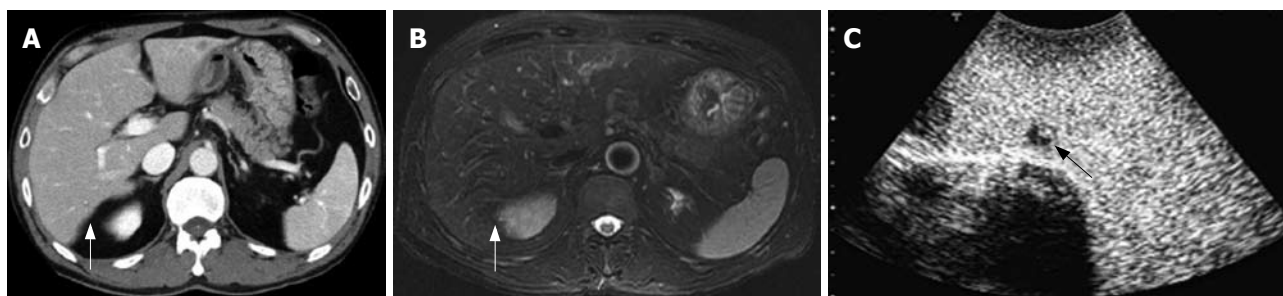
Preoperative CT and SPIO-MRI, and CE-IIOUS. A: An enhanced-CT could not detect any lesion at the Segment 6 (arrow); B: A SPIO MRI view could not detect any lesion at the Segment 6 (arrow); C: CE-IIOUS view at the delayed Kupffer phase and a small hypoechoic mass partially containing an isoechoic lesion was detected by CE-IIOUS.
